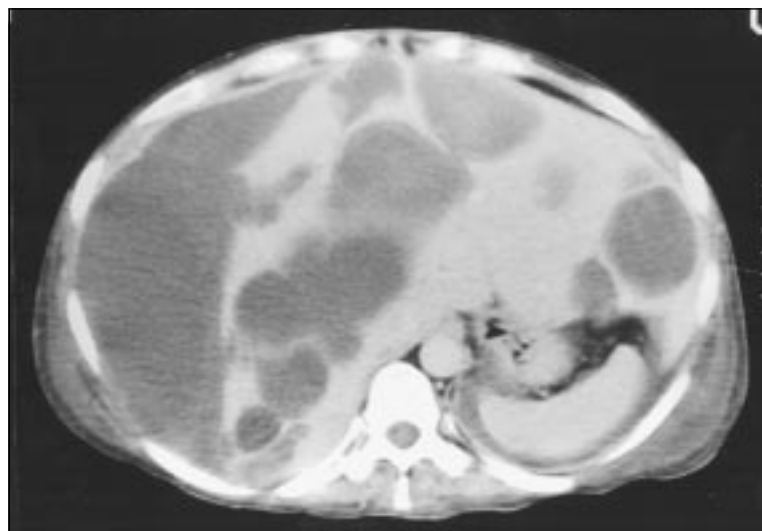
Computed tomogram of abdomen more than one year after diagnosis of choriocarcinoma. Darker areas show multiple large, intrahepatic, fluid filled cysts at site of previous hepatic metastases
